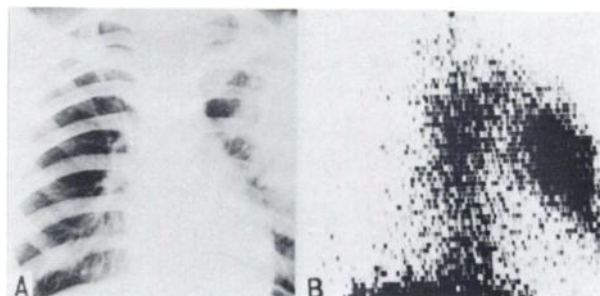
(A) Chest x-ray shows exudative lesions in left upper and middle lung field. (B) Scintigram is strongly positive.
